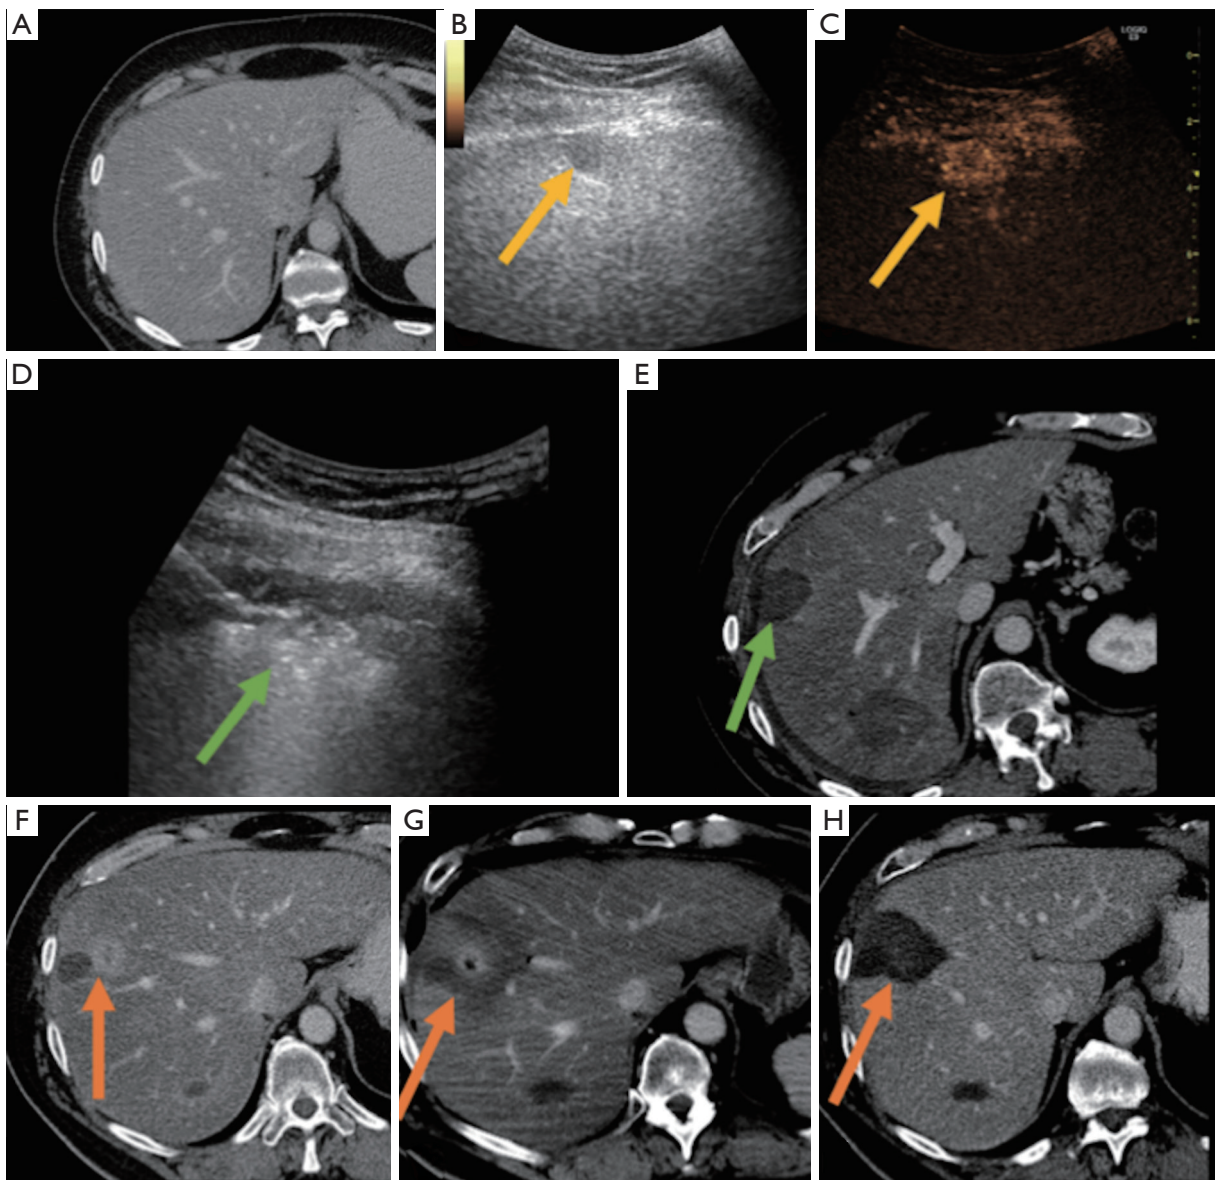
Example of local tumor progression with retreatment. (A) Segment VIII lesion in a 62-year-old male is radiographically occult on CT but visible by ultrasound. (B,C) US of lesion (yellow arrow) without and with US contrast. (D) Intra-procedural US demonstrating gas bubbles covering entire lesion (green arrow), and (E) post-ablation CT of lesion demonstrating appropriate coverage (green arrow). (F) New area of nodular enhancement detected along the medial ablation margin (orange arrow) 3 months post-ablation, consistent with LTP. (G) Repeat ablation shows appropriate coverage of LTP (orange arrow) without residual enhancing tissue. (H) Follow-up scan 4 months after retreatment demonstrates no recurrence (orange arrow). LTP, local tumor progression.
